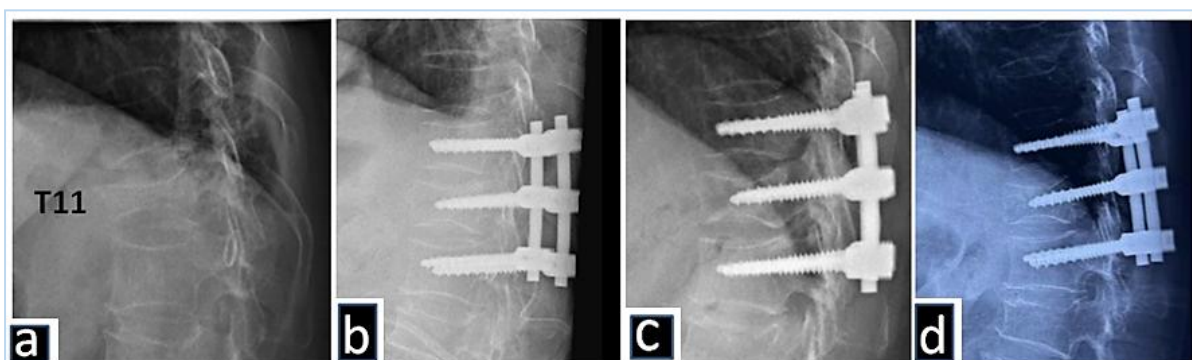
A 70-year female with T11 burst fracture (AO A4). Postoperative X-ray (b) shows improvement in kyphotic angle from preoperative radiograph (a), which is maintained on subsequent follow-ups at 1 month (c) and 1 year (d)
